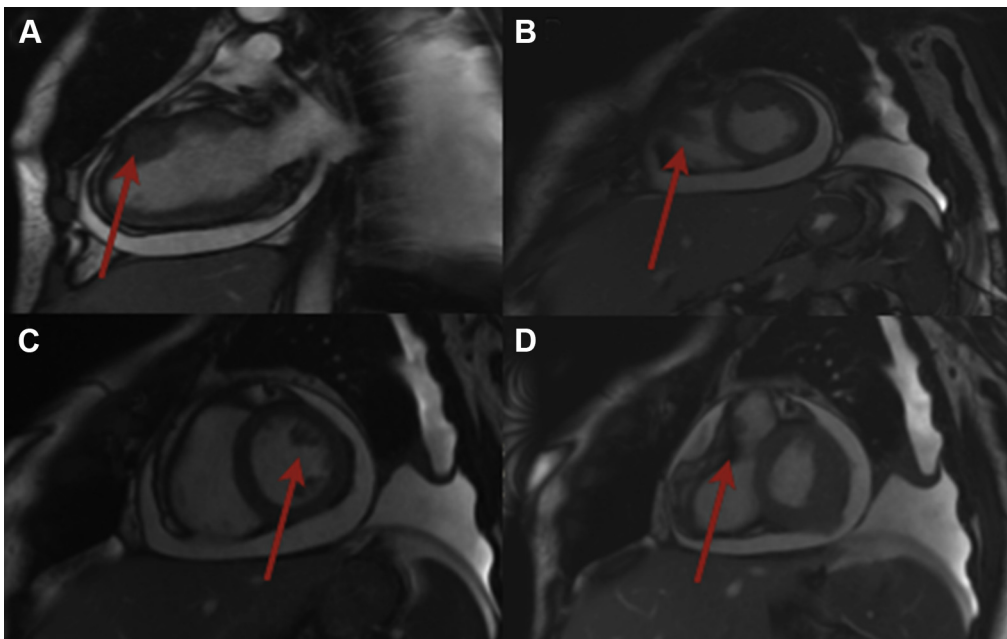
Cardiac MRI images showing intramural mass anterior mid-left ventricle (A), basal right intra-ventricular mass (B), left intra-ventricular mass (C) mass within right ventricular outflow tract (D).
